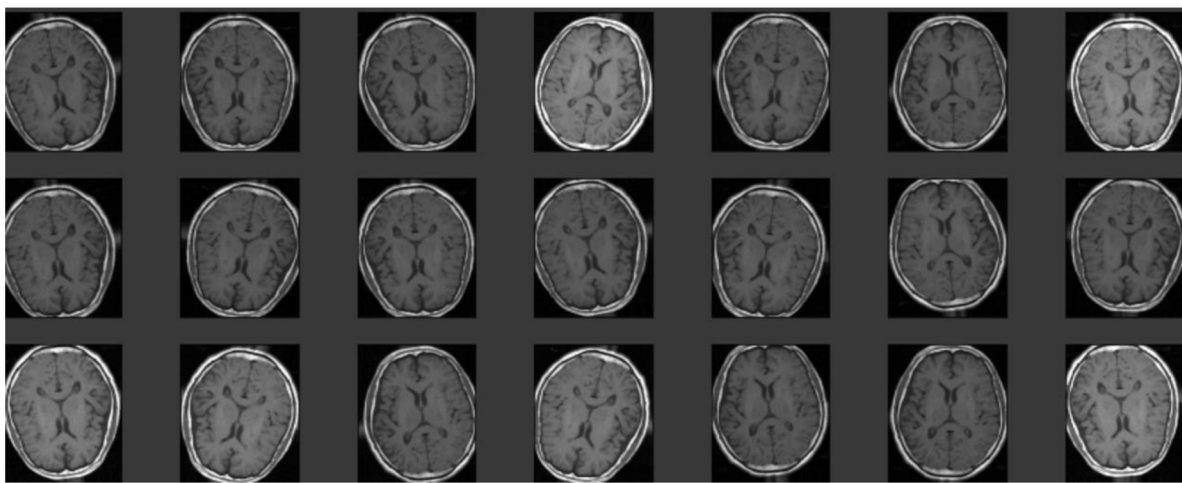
Data augmentation of the brain MRI images. It increases the amount of training and test data for designing and evaluating an effective model. (Own work).
